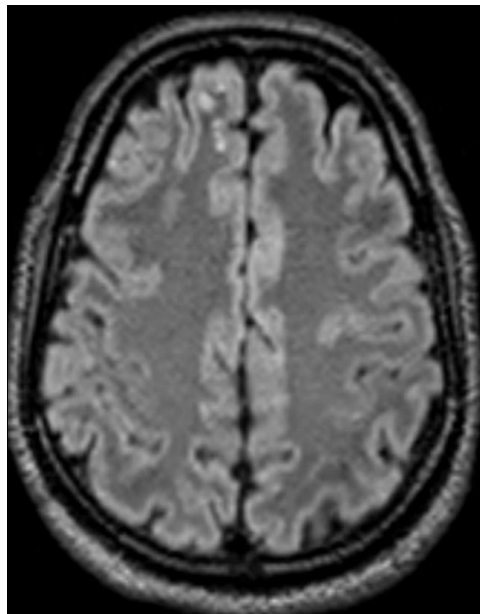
Axial T2 FLAIR showing non suppression of the cystic areas and absence of any white matter edema
